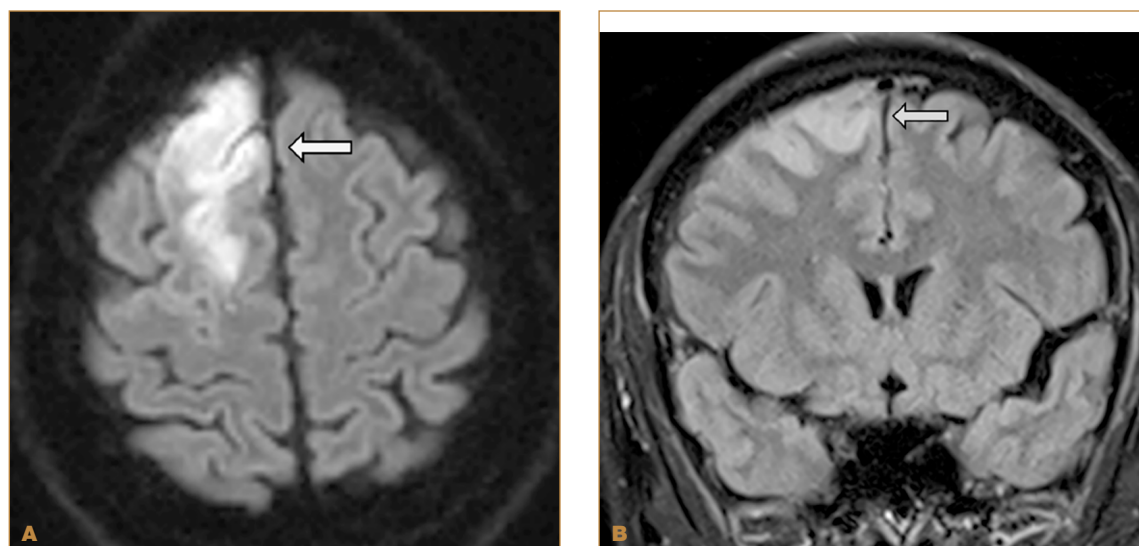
MR imaging of 2nd patient
